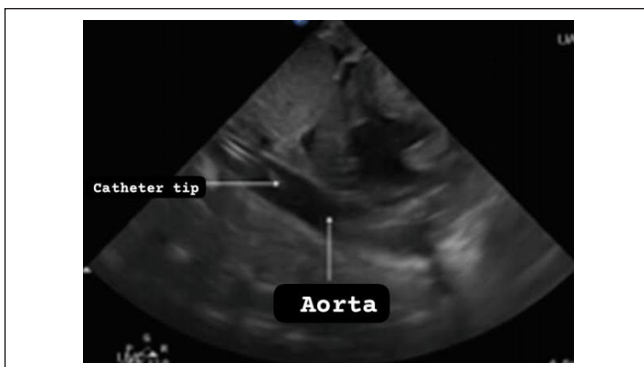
Catheter tip in the abdominal aorta as seen by point of care ultrasound
